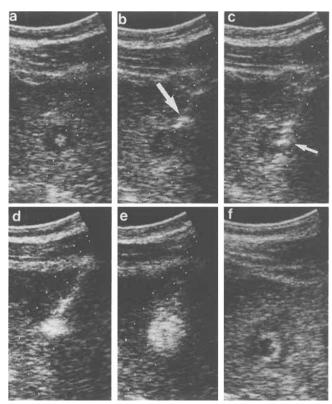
Patient 12: Ultrasonograms before, during, and after PMCT. (a) Before treatment. (b) The guide needle (white arrow) was inserted. (c) The microwave electrode (white arrow) was inserted into the interior of the tumor. (d) The tumor was irradiated. (e) Microwave irradiation was finished. (f) One week after PMCT. The image of the tumor changed from low echo with a high-echo spot to a mixed pattern after PMCT.
